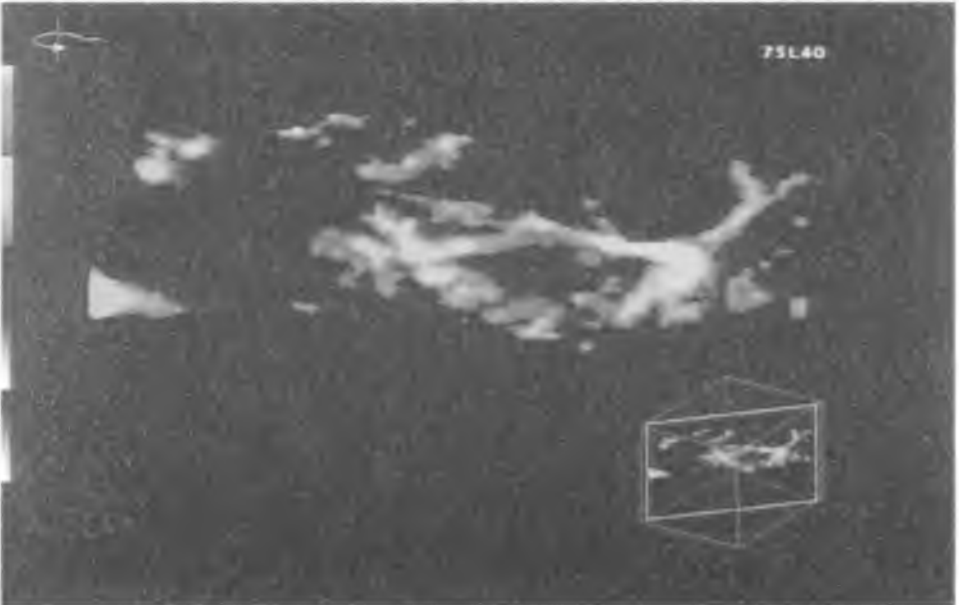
Visualisation of a lymph node vessels in 3D presentation, with Power Doppler mode
